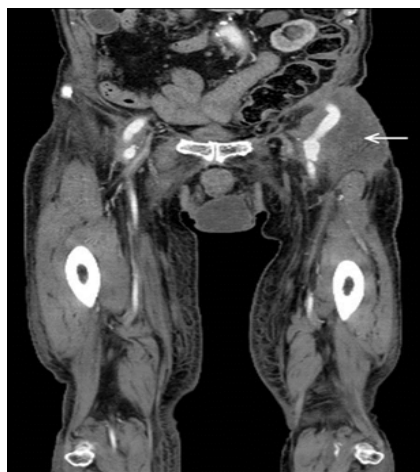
Follow-up CT demonstrated no fluid surrounding the graft (arrow: muscle flap).
